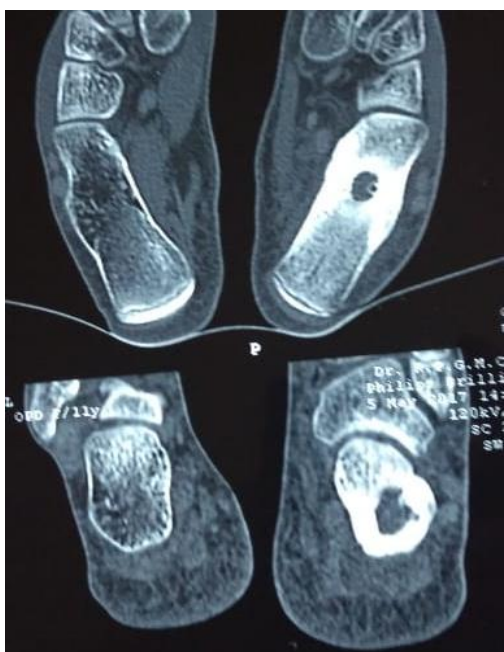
Hyperdense lesion seen in the body of left calcaneum on CT scan.
